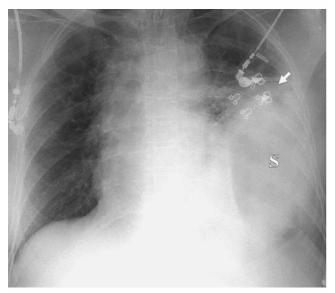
Admission chest X-ray shows an elevation of the stomach (S) associated with a left lung atelectasis (arrow).
